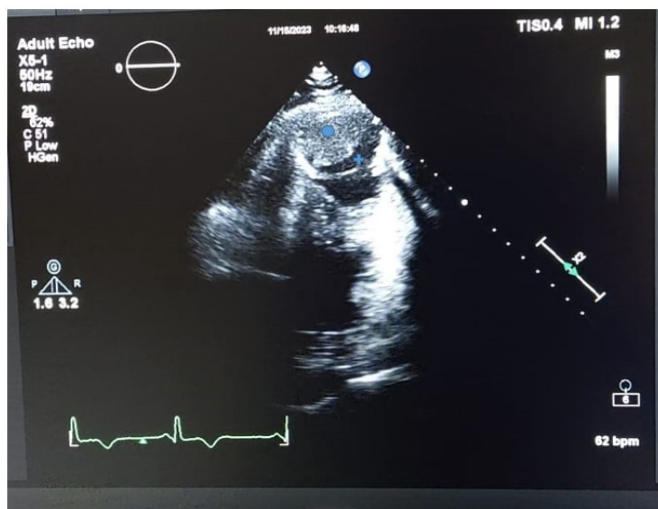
Two-chamber echocardiography image shows an aneurysmatic area with hypoechoic fluid
